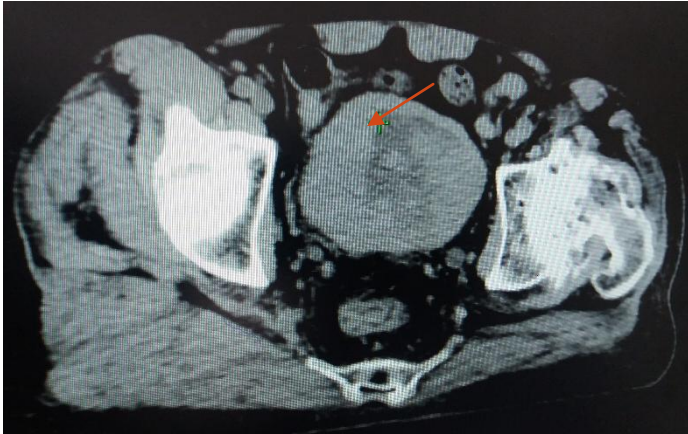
(CT scan): Large intravesical tumor
